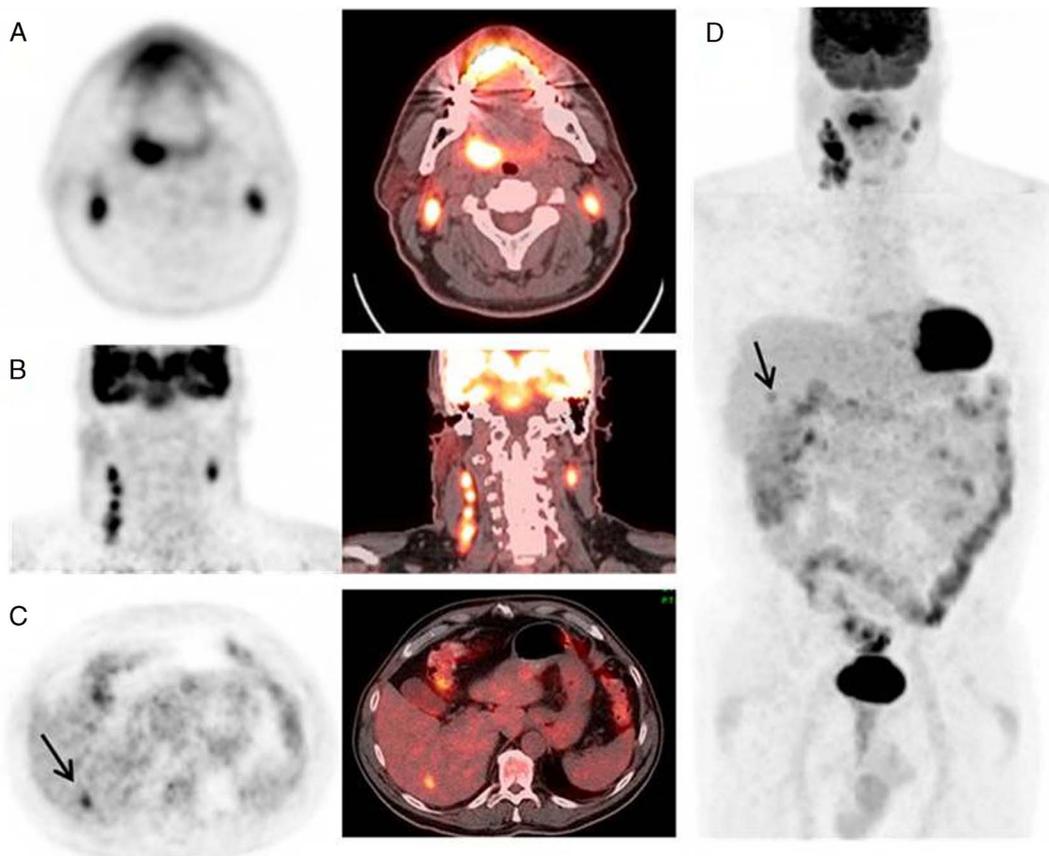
Staging distant metastasis. A 64-year-old man with moderately differentiated, p16 positive, squamous cell carcinoma of the right tonsil. Axial PET and PET/CT fused images (A) showed FDG-avid primary tumor at right tonsil and bilateral level II lymph nodes, coronal PET, and PET/CT fused images (B) showed bilateral multiple metastatic lymph nodes. ^{18}F -FDG PET/CT demonstrated an 11-mm right hepatic FDG-avid lesion (C). MIP images (D) showed primary tumor with regional metastatic lymph nodes and distant liver metastasis (T2N2bM1).
